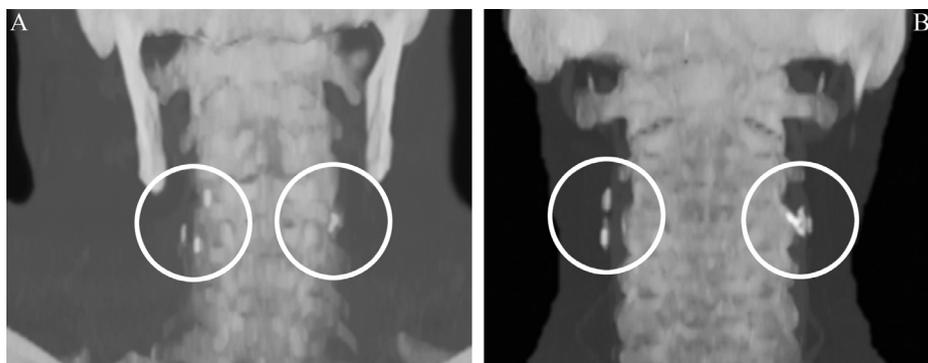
Computed tomography angiography images with maximum intensity projection (MIP) showing examples of calcifications corresponding to the different grades of superimposition of calcified carotid plaques on the cervical spine. A, *Covered*, where all the calcification in the carotid plaque is completely covered by the vertebrae, within the circle on the patient's left side; and *Mostly covered*, where more than half of the calcification is covered, within the circle on the patient's right side. B, *Mostly free*, where less than half of the calcification is covered by the vertebrae, within the circle on the patient's left side; and *Free*, with no superimposition of the calcification, within the circle on the patient's right side.
